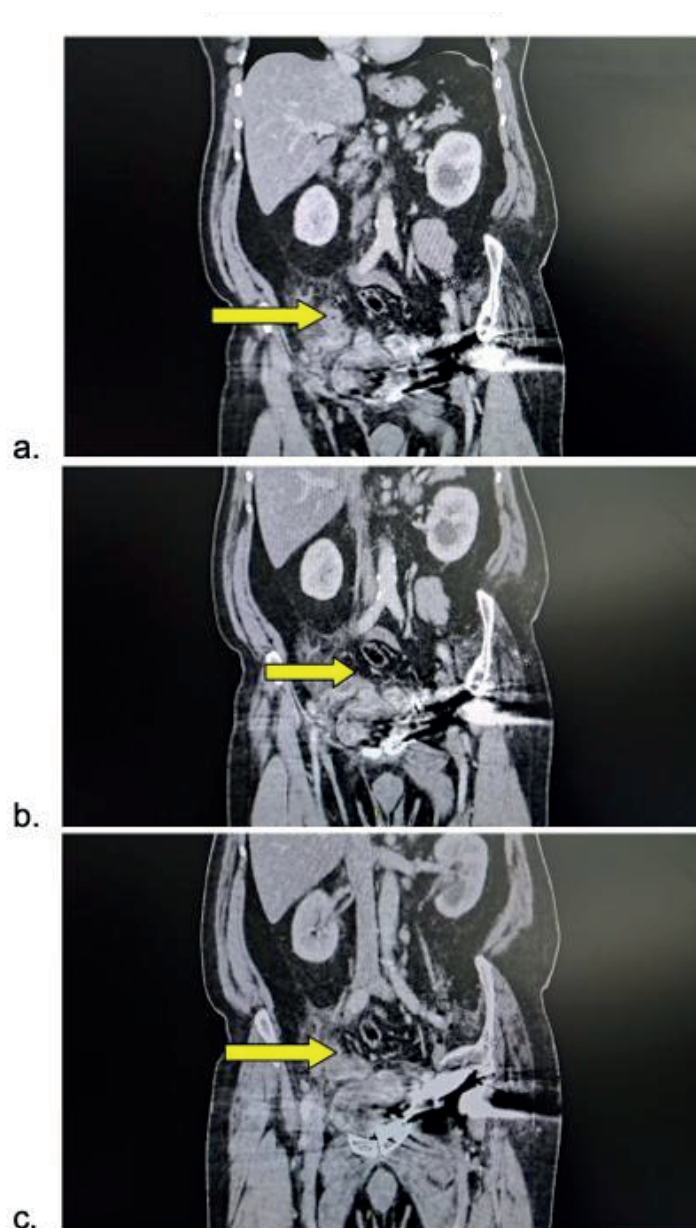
Pre-operative CT scan of abdomen and pelvis with contrast where the green line shows thick appendix and fat stranding.
